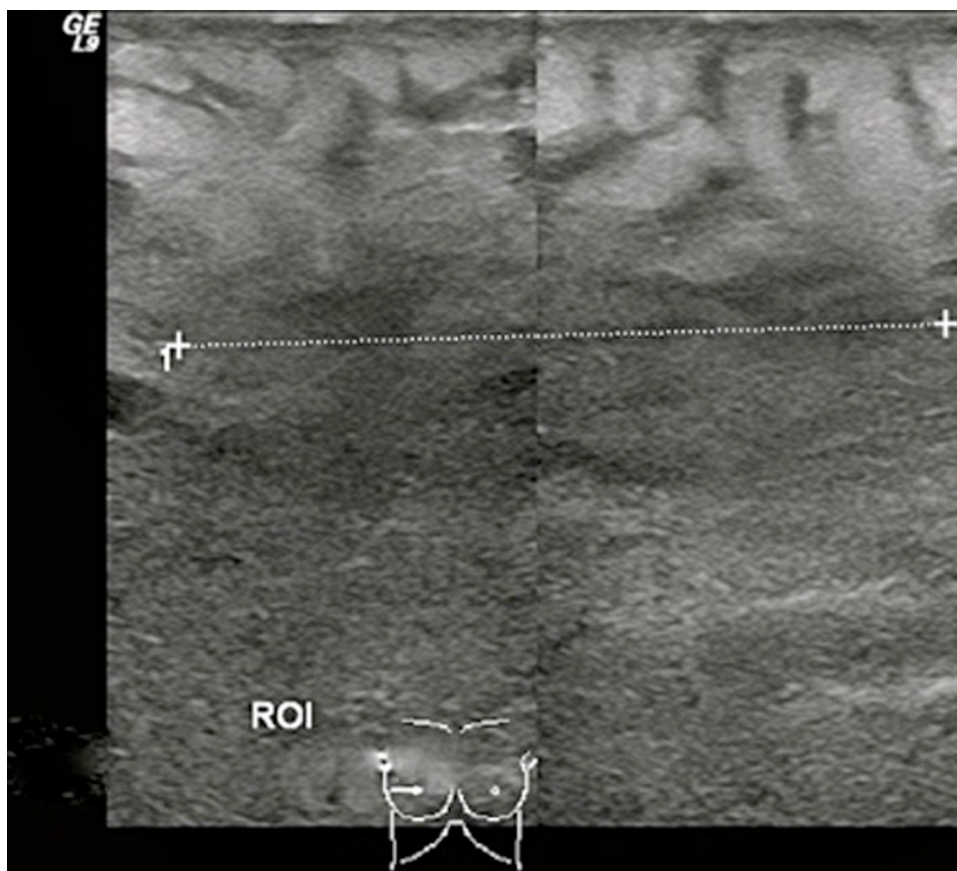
Right breast ultrasound: diffusely oedematous tissue throughout the breast with an irregular hypoechoic mass at the lateral aspect of the breast in the 9 o'clock position.
